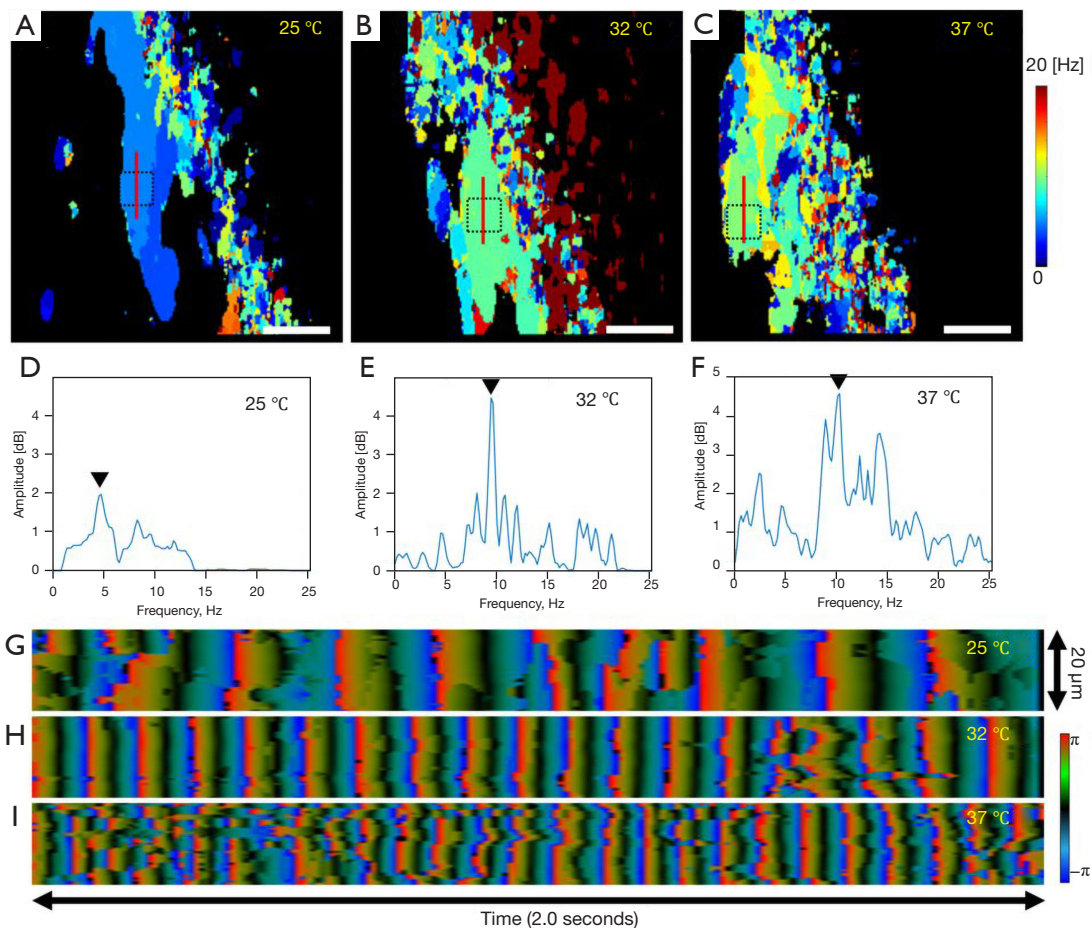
Analysis of the cilia beating characteristics at different temperatures. (A–C) Spatial distribution of cilia beating frequency map at 25, 32, and 37 °C. (D–F) Doppler power spectrum density function profiles at the location indicated by the dotted boxes, where the peak (black triangles) corresponds to the dominant CBF. (G–I) Temporal changes of phase in dynamic wavefront images at the location indicated by the red lines in (A–C). Scale bars indicate 20 μm . CBF, cilia beating frequency.
